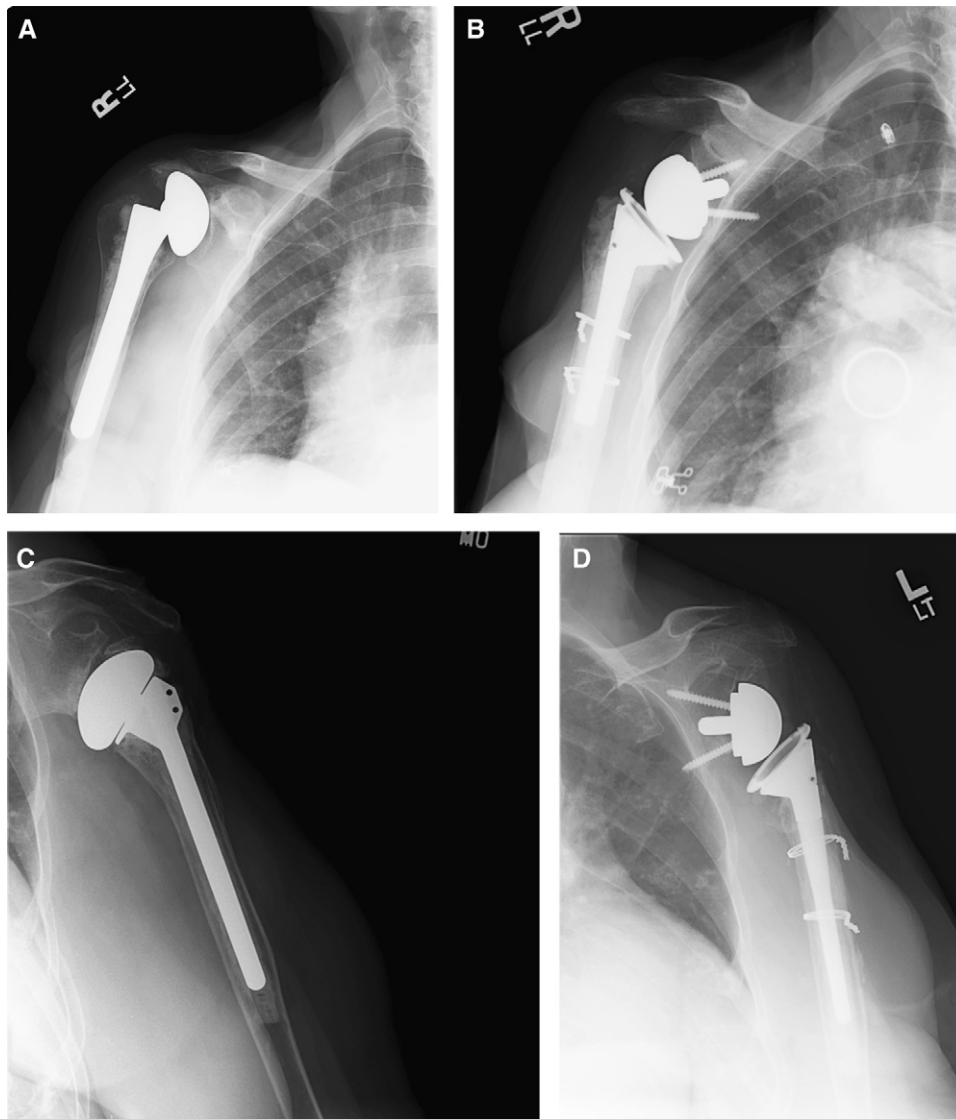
(A) A preoperative x-ray image. (B) A postoperative x-ray image shows placement of cerclage wires. (C) A preoperative x-ray. (D) A postoperative x-ray image shows placement of cerclage wires.
